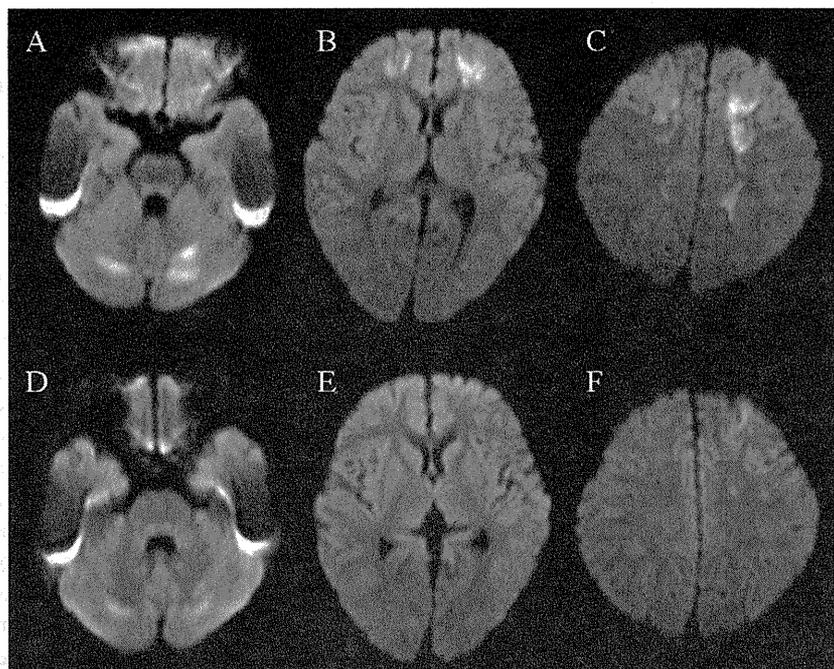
MRI findings in case 1. (A–C) Axial DWI on day 3 showed marked hyperintensity in the left hemisphere, dominant bilateral front-parietal white matter, and bilateral dentate nucleus. (D–F) Axial DWI on day 10 showed no new abnormal lesions and a decrease in size of the abnormal lesion.
